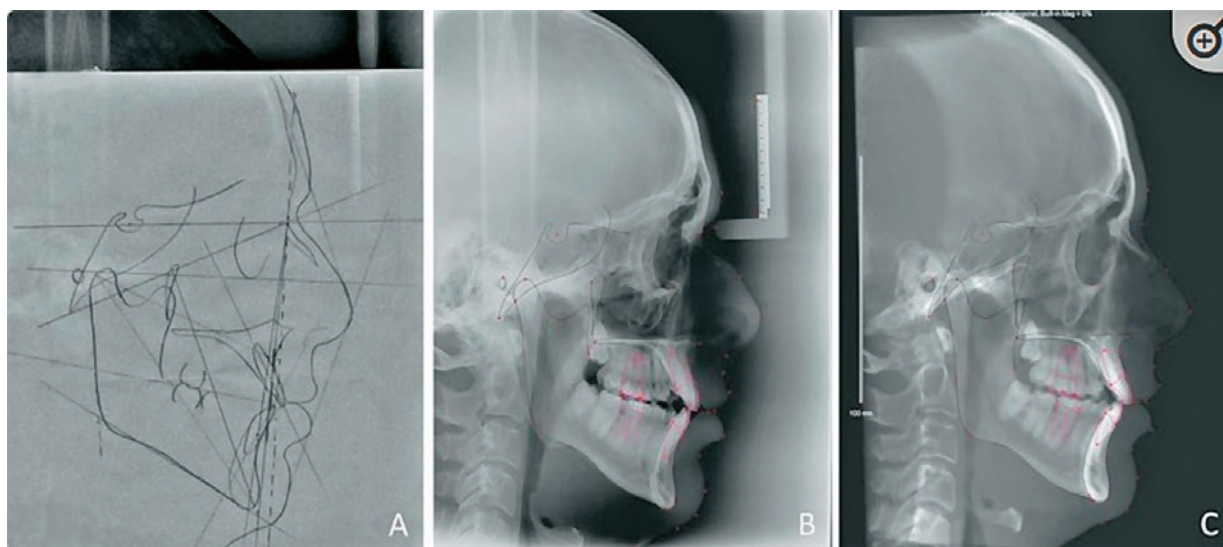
A) Manual cephalometry; B) Digital, 2D, LL cephalogram; C) 3D, CBCT, LL cephalogram
